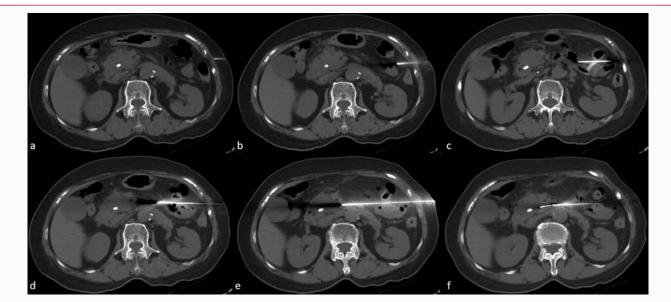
CT-guided coaxial core needle biopsy with the detour technique in a 68-year-old woman with a pancreatic uncinate process tumor. a) Non-enhanced axial CT image showed 17-gauge coaxial needle inserted in the subcutaneous layer. b-e) Non-enhanced axial CT images showed the coaxial needle advanced in a stepwise manner into the pancreatic uncinate process mass by delicately changing its angulations to avoid non-target organ penetration. f) After the coaxial needle successfully reached the pancreatic uncinate process mass, the biopsy needle was fired into the lesion.
